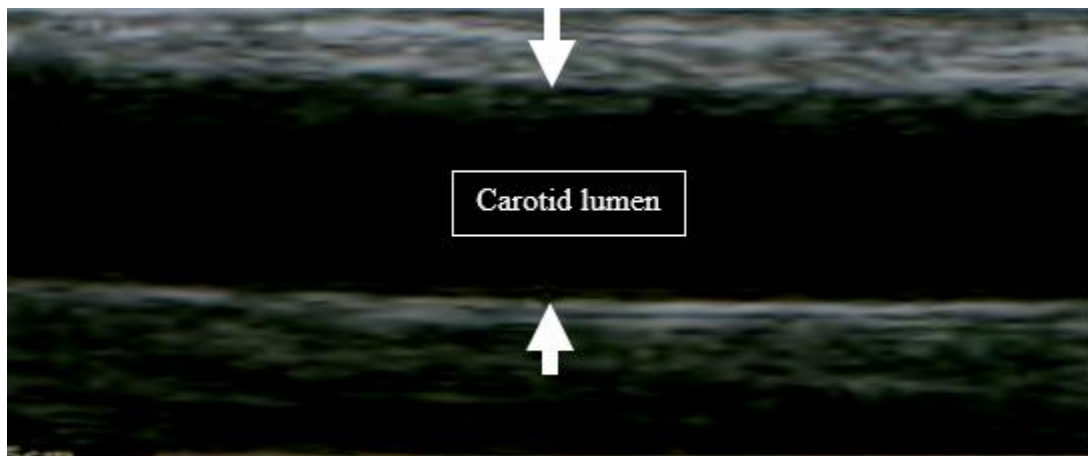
Greyscale ultrasonography (longitudinal view) showing method of measurement of the carotid luminal diameter in CCA and ICA.
